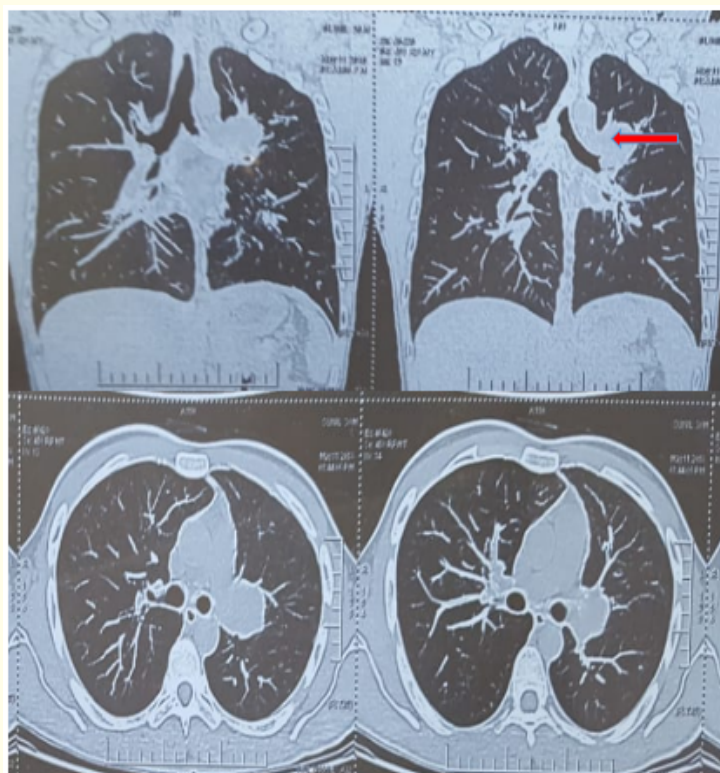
and 1B: Computed tomography shows ill-defined soft tissue attenuation in the left superior hilar region 3.6 x 3.7 cm in size.
